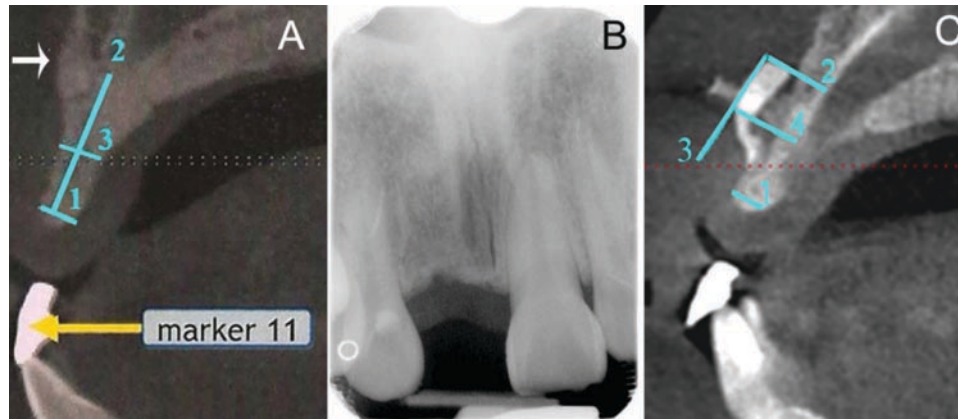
CBCT (A) and radiographic peri-apical view (B) at the implant site (tooth 11) show definite implant position with Seibert's classification I (1 = 2.46 mm, 2 = 11.10 mm, 3 = 3.02 mm) and odontoma is presented (white arrow), CBCT after 4 months (C) of bone augmentation showed bucco-lingual width of 5.15 mm (1 = 2.7 mm, 2 = 5.27 mm, 3 = 10.55 mm, 4 = 5.15 mm).
